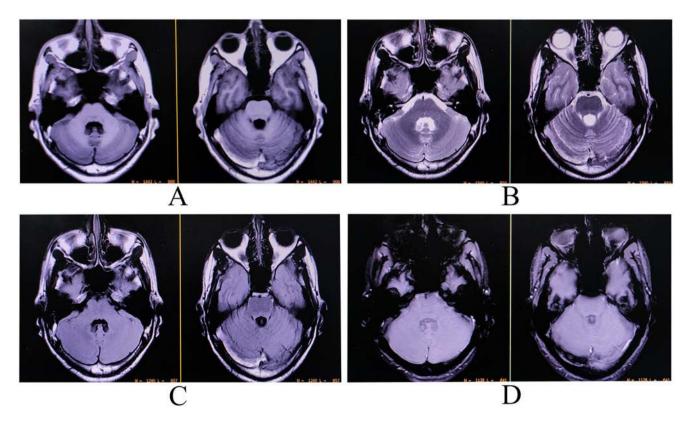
Magnetic resonance imaging of the brain reveals hyperintense lesions on axial T1-weighted (A), axial T2-weighted (B), and axial T2-FLAIR (C) imaging, with signal blooming on the axial gradient echo sequence (D), involving the right cerebellar hemisphere. These findings are suggestive of thrombosis with hemorrhage involving the right transverse venous sinus and the Torcular Herophili.
